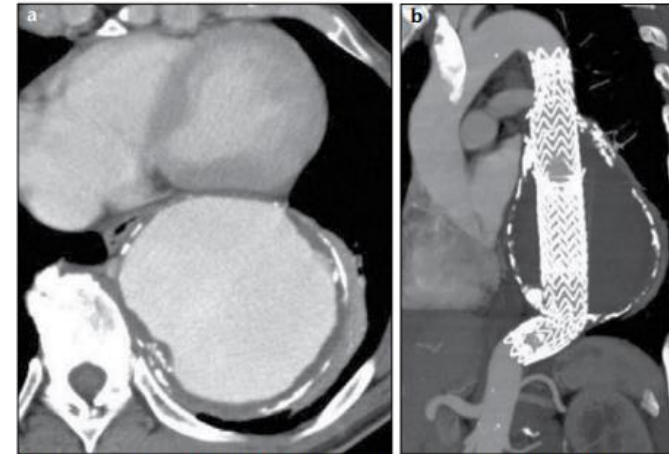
a, b. CT image of the huge descending thoracic aortic aneurysm before (a) and maximum intensity projection image after (b) thoracic endovascular aortic repair (TEVAR). The preoperative diameter of the aneurysm was 90 mm. The descending thoracic aortic aneurysm was treated by TEVAR without any endoleak.
